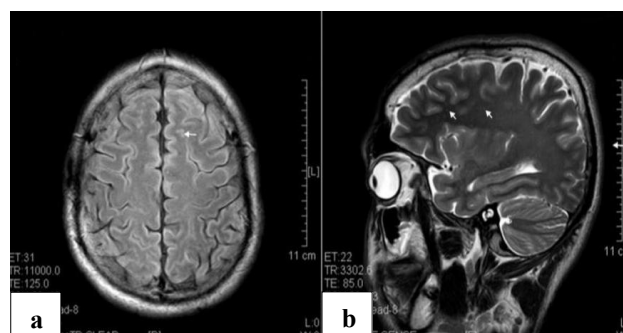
Hyperintense spots (arrow) in the superficial white matter and internal capsule of ketamine addicts, (a) FLAIR imaging of a 1-year ketamine addict, and (b) T2 imaging of a 3-year ketamine addict.⁹
